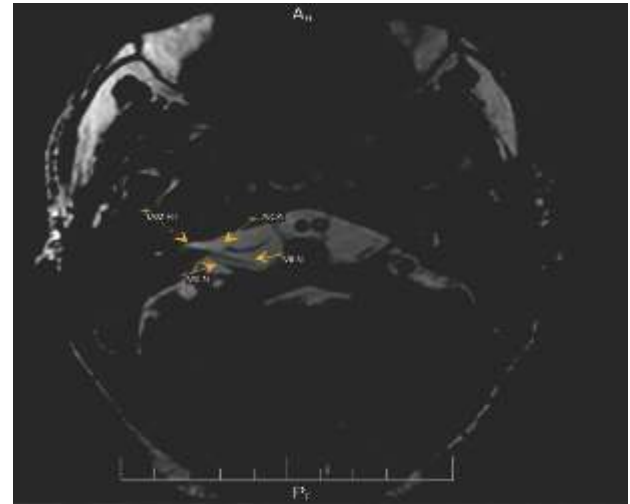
MRI 3-D axial FIESTA sequence outlining AICA in the CSF of right cerebellopontine angle. The vessel is seen crossing over the VII/VIII nerve at the level of porus acusticus without entering the internal auditory meatus (type I variant).
